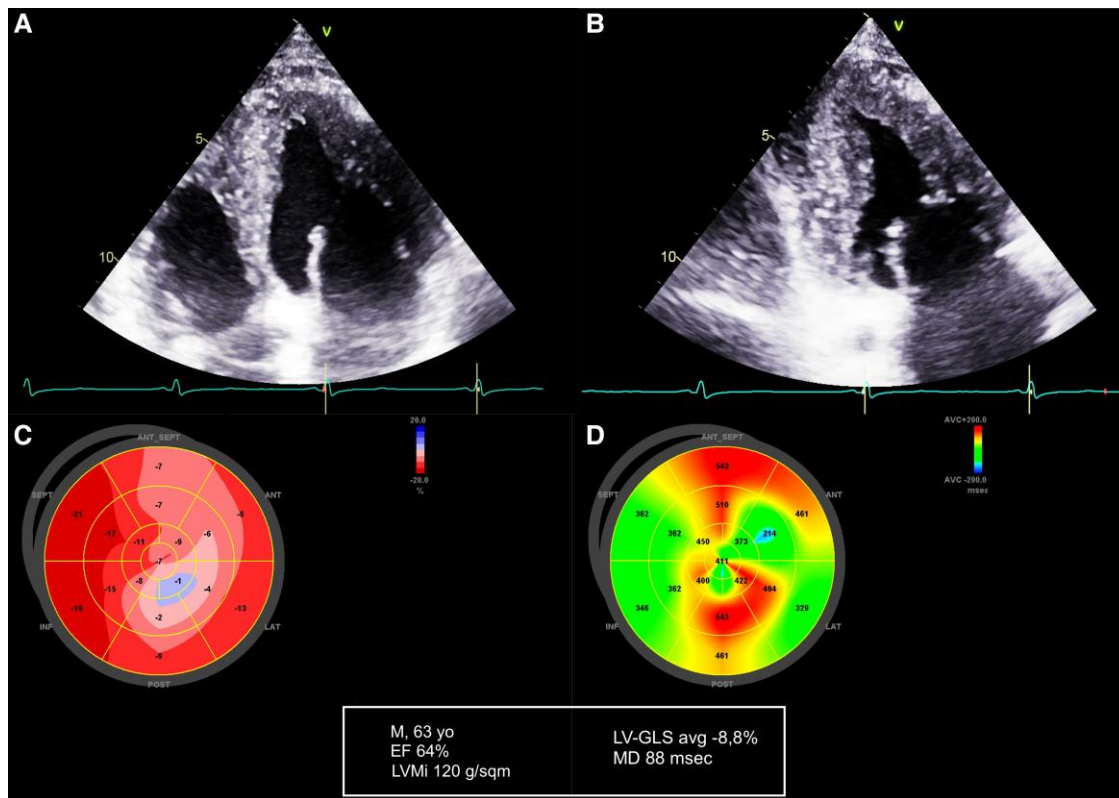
Patient with hypertrophic cardiomyopathy. (A) Apical four-chamber view; (B) apical two-chamber view; (C) global longitudinal strain; (D) mechanical dispersion.
